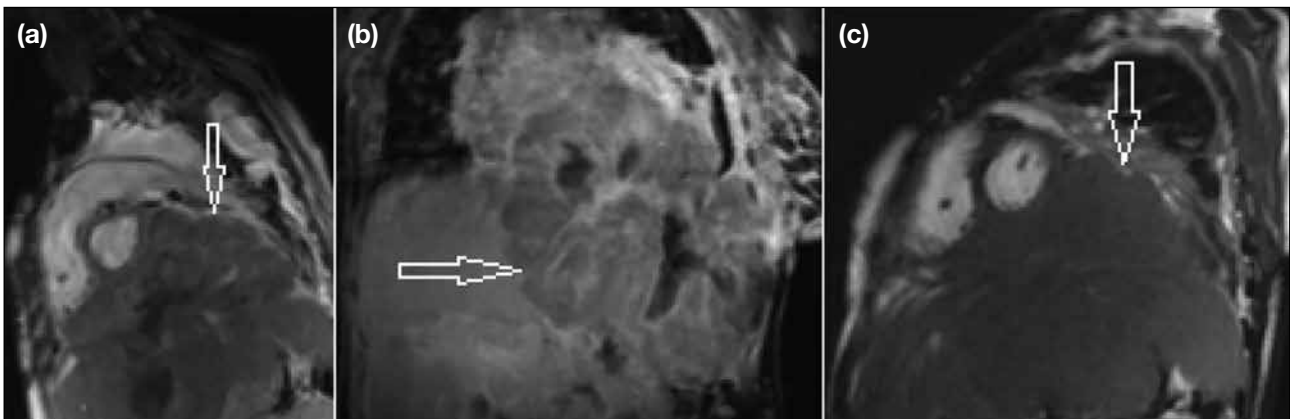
Cardiac magnetic resonance images in sagittal (a), coronal (b), and short axis (c) views of a 57-year-old female patient who was diagnosed with primary hepatic sarcoma arising from the left lobe of the liver. (a), (b), and (c) demonstrate the presence of a large mass invading the heart with atrial, vascular, and ventricular involvement, respectively (arrows).
